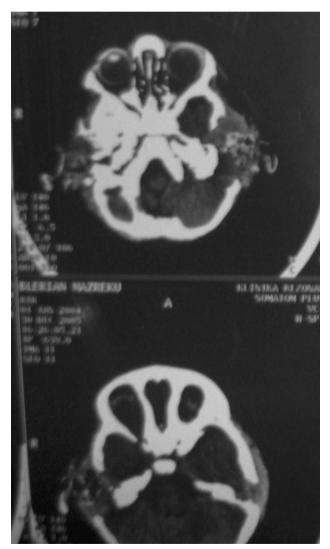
Computed tomography of the cranium shows bone destruction of both temporal bones; both tympanic clefts are filled with soft tissue masst.
